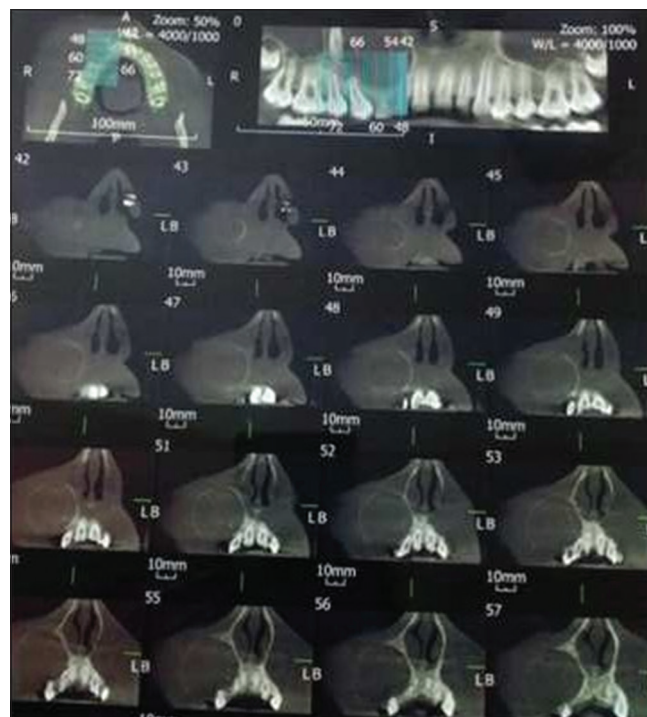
CBCT reveals radiopaque flecks with thinning of the buccal cortical plate with expanded osteolytic lesion and presence of 13 in the vicinity of the right maxillary sinus
